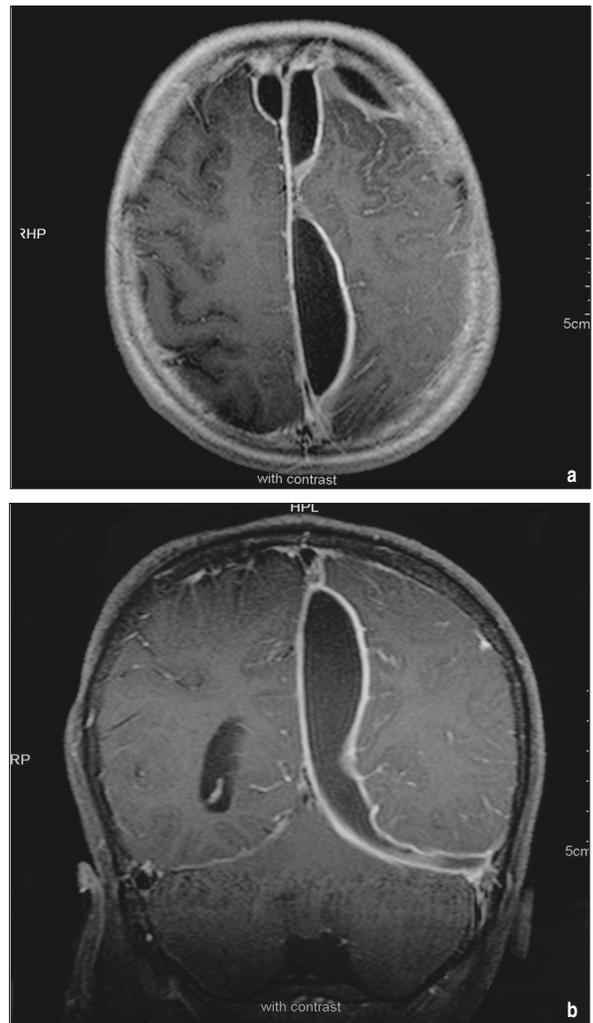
MRI view of interhemispheric subdural abscess (white arrows) a) transverse view, b) coronal view.
